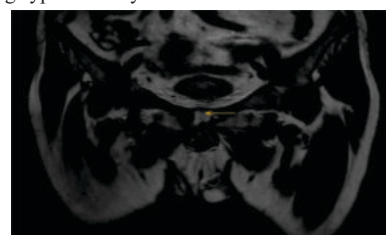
3 MRI T2 coronal section shows fluid within the pubic
